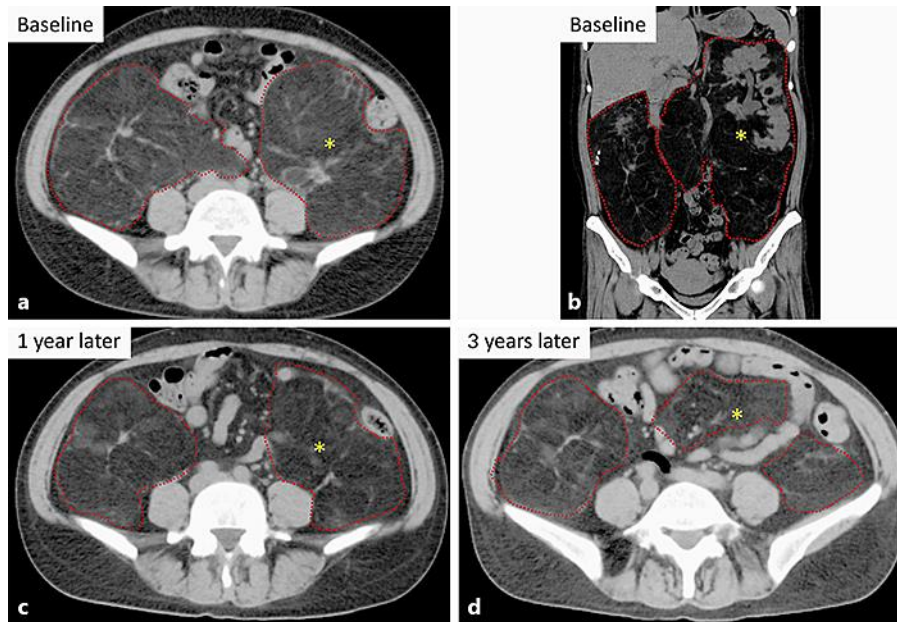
Case 1. a, b Computed tomography (CT) reveals huge RAMLs before initiation of everolimus therapy. The maximum diameter of the biggest RAML (asterisk) is 21.8 cm. c CT shows huge RAMLs at 1 year after initiation of everolimus therapy. The maximum diameter of the biggest RAML (asterisk) is 18.5 cm. d CT shows huge RAMLs at 3 years after initiation of everolimus therapy. The maximum diameter of the biggest RAML (asterisk) is 17.3 cm.
